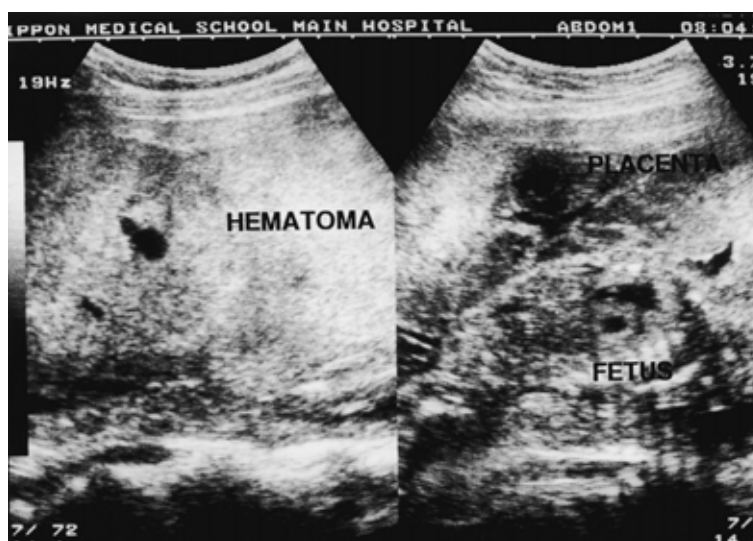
A large homogenous and hyperechoic zone detected at the lower pole of the placenta at 23 weeks' gestation by ultrasonography
